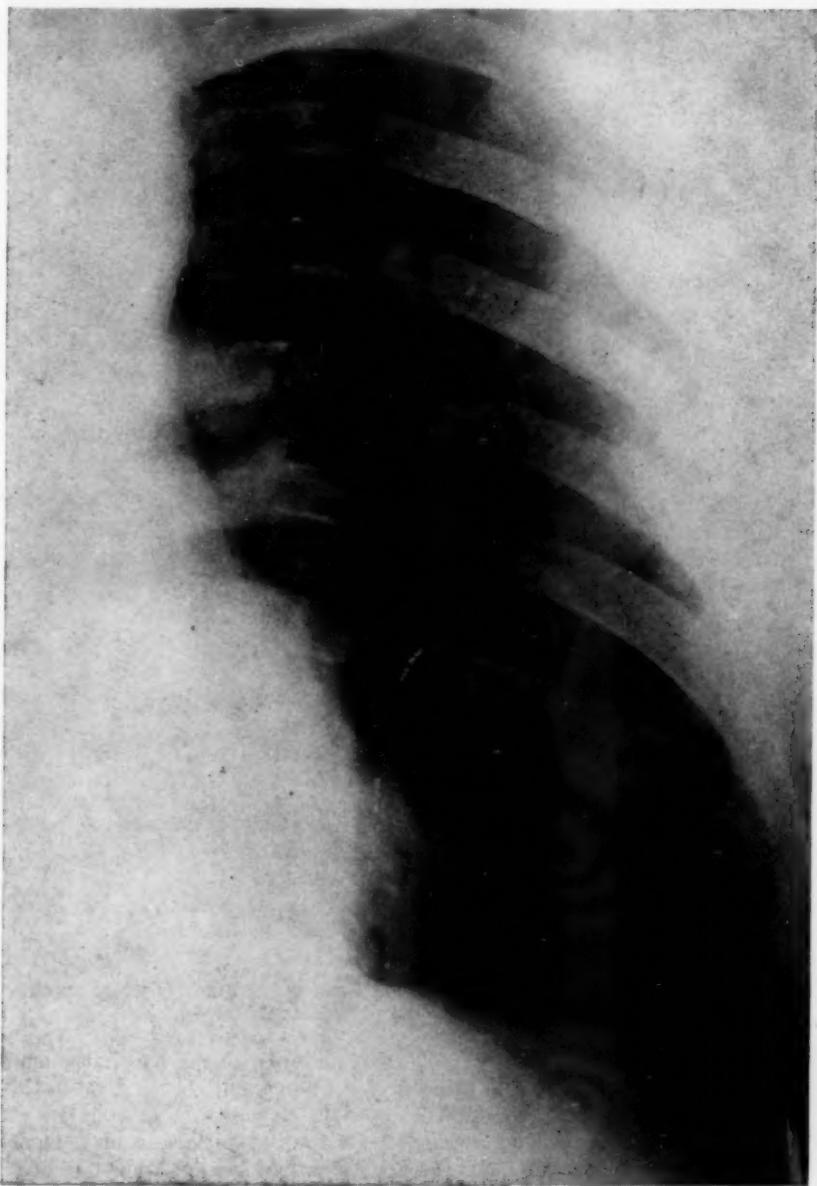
Case 1.* PA roentgenogram showing a small round opacity at the level of the fourth rib anteriorly.
